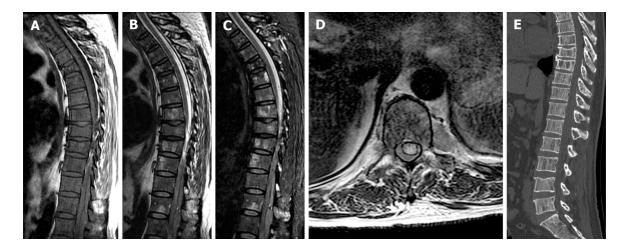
Magnetic resonance imaging showed a posterior epidural mass located from Th11 to L1. A: Sagittal T1-weighted imaging (T1WI); B: T2weighted imaging (T2WI); C: T2-weighted fat-saturation imaging; and D: Axial T2WI showing an epidural mass compressing the spinal cord. Diffuse patchy areas of isointense signal on T1WI and slightly hyperintense signal on T2WI were seen in all vertebrae; E: Computed tomography showed multifocal osteolysis and clearly defined cortical margins of the vertebrae from Th11 to L1. The Th8 and Th9 vertebral bodies had collapsed, indicating a compression fracture caused by myelomainduced bony destruction.
